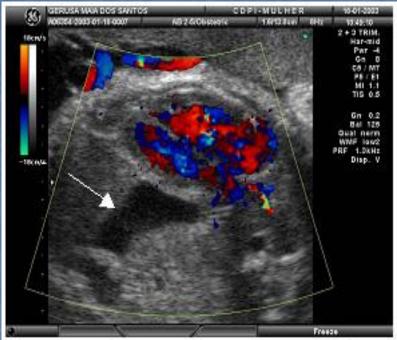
Ultrasound axial view showing the typical image of the left diaphragmatic hernia. Note the heart placed to the right side and the stomach in the same plane (arrow).
